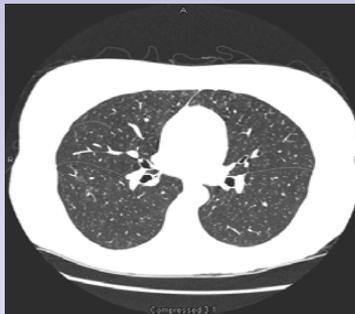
Chest CT obtained six weeks after initiation of systemic steroid scan showing marked improvement of the diffuse hazy nodules.
